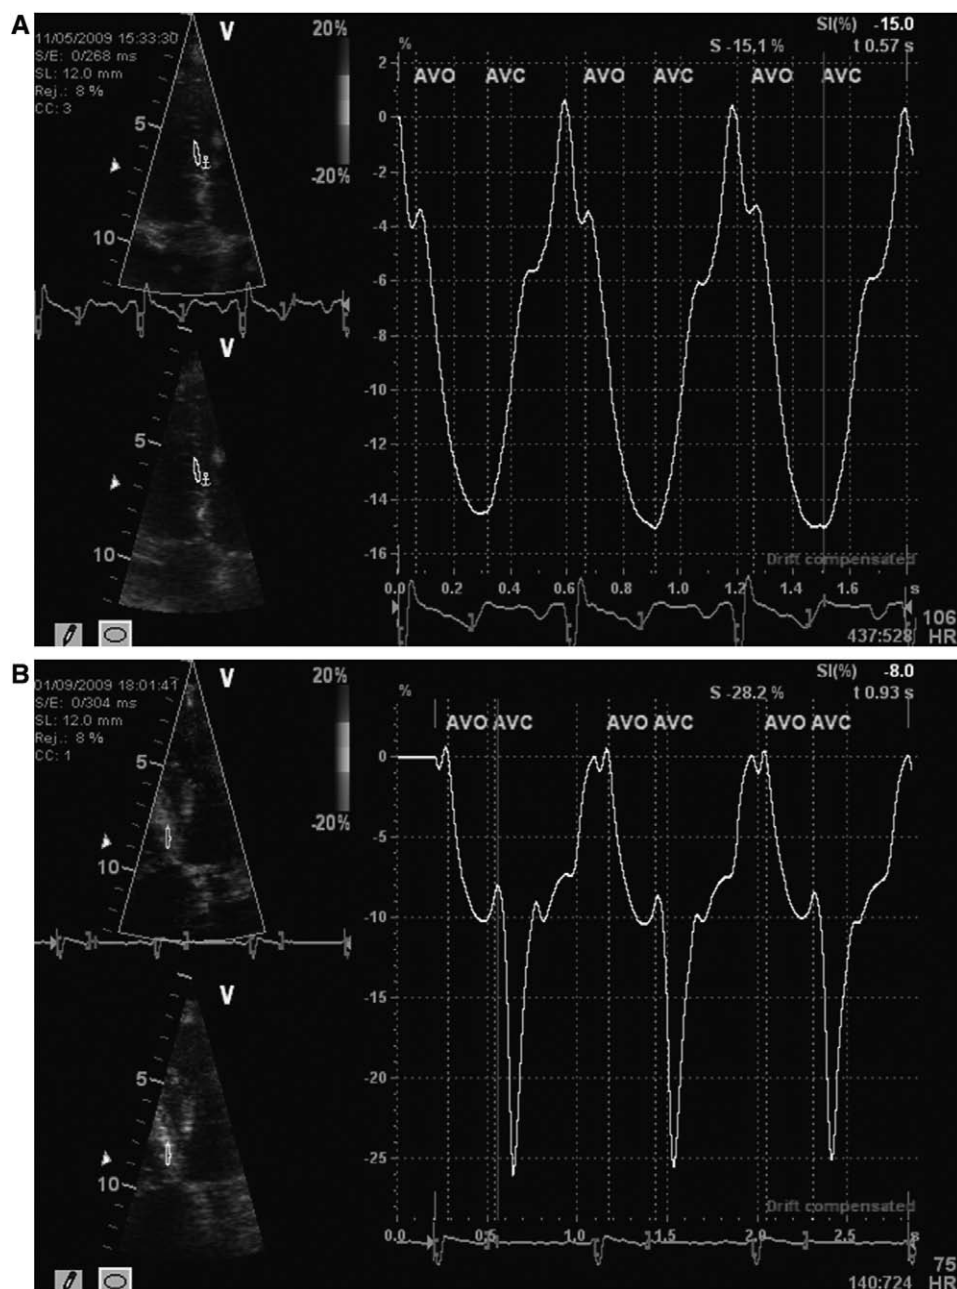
Color tissue Doppler (CTD)-derived strain curves at the level of the mid (A) and basal (B) septum in a pregnant control and an Afro-Caribbean patient with preeclampsia aged 26 years at 32 weeks of gestation. The case and control are matched for ethnicity, maternal age, and gestational age at assessment. It is possible to appreciate the reduced end systolic strain (10%) and the presence of high-amplitude postsystolic shortening (yellow arrow) in the woman with preeclampsia (B) vs a normal end systolic strain (15%) without postsystolic deformation in the control (A). This abnormal deformation pattern is suggestive of impaired myocardial contractility in the woman with preeclampsia. AVC indicates aortic valve closing; and AVO, aortic valve opening.
